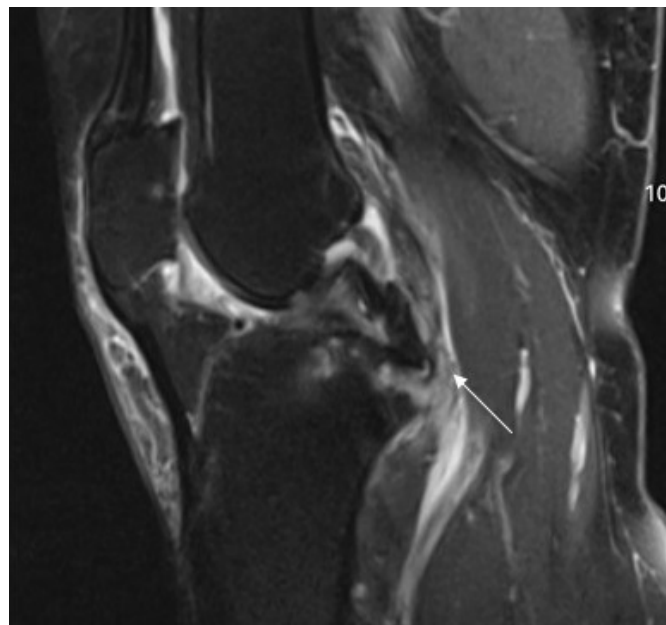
Preoperative knee MRI demonstrating an avulsion fracture at the tibial insertion of the posterior cruciate ligament (PCL), with associated intrinsic ligament injury.
